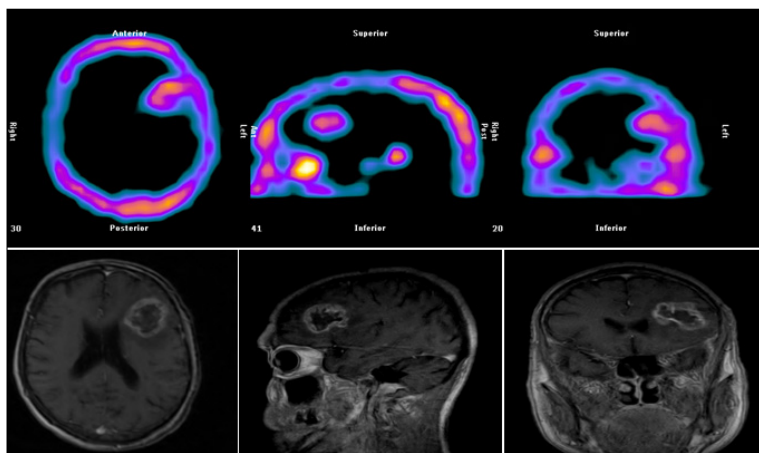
Early stage brain SPECT with 99mTc-MIBI. Pre-operative skull and T1-weighted MRI.
